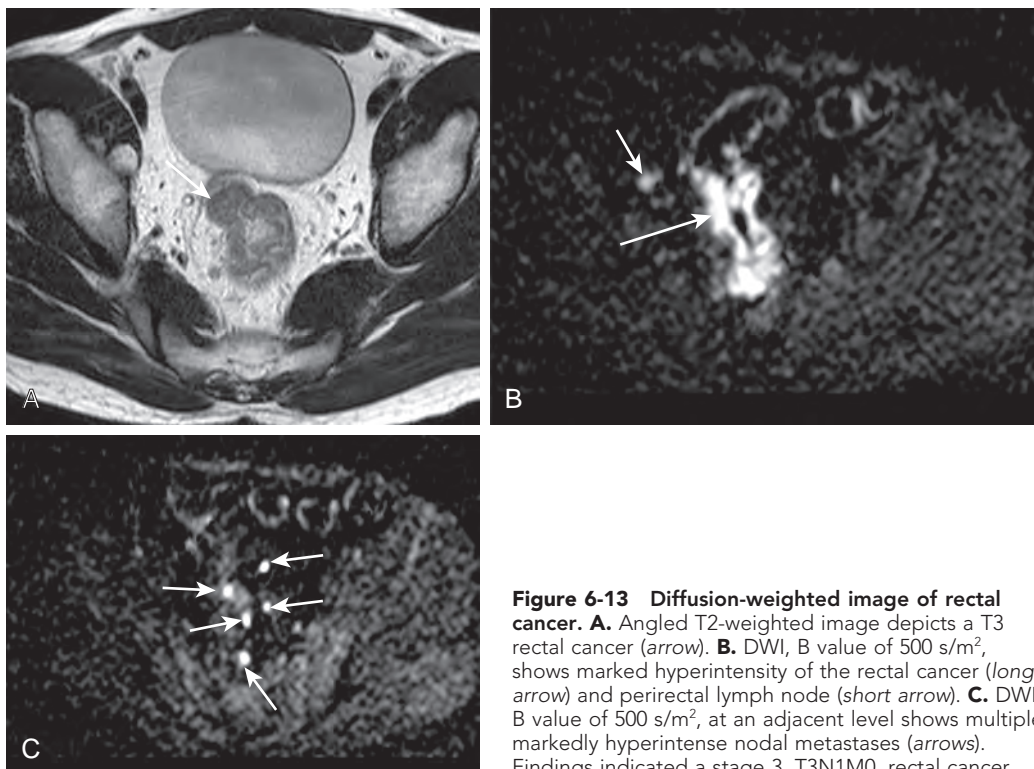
Diffusion-weighted image of rectal cancer. A. Angled T2-weighted image depicts a T3 rectal cancer (arrow). B. DWI, B value of 500 s/m², shows marked hyperintensity of the rectal cancer (long arrow) and perirectal lymph node (short arrow). C. DWI, B value of 500 s/m², at an adjacent level shows multiple markedly hyperintense nodal metastases (arrows). Findings indicated a stage 3, T3N1M0, rectal cancer.
